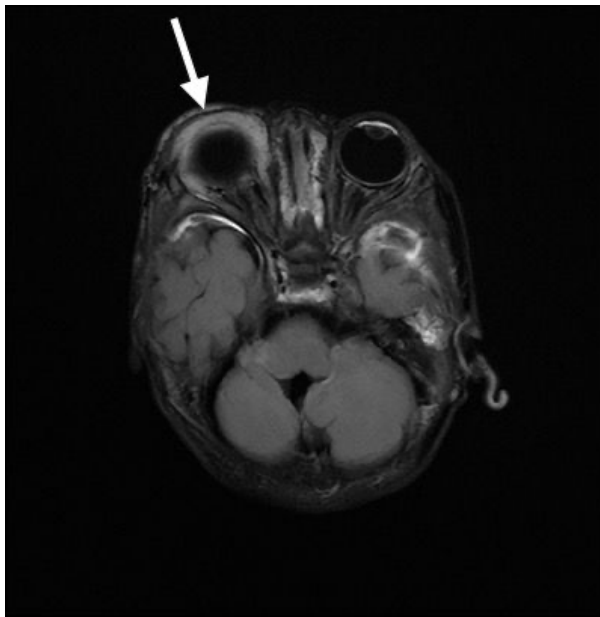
Axial T2-weighted MRI demonstrating a hyperintense mass in the right peri-orbital region (arrow) with post-septal extraconal extension.
